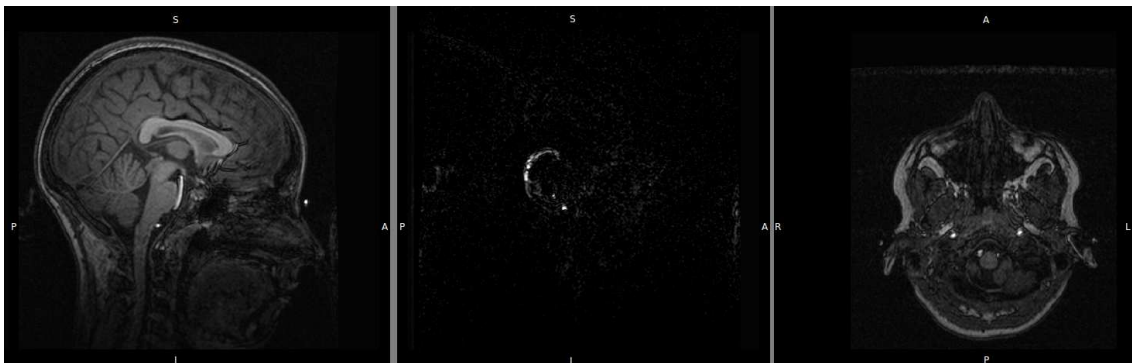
Fiducials on T1 MRI. The sagittal image on the left shows the nasion, the sagittal view in the middle shows two gadolinium markers on the right ear, and the coronal view on the right shows one left and one right marker.
